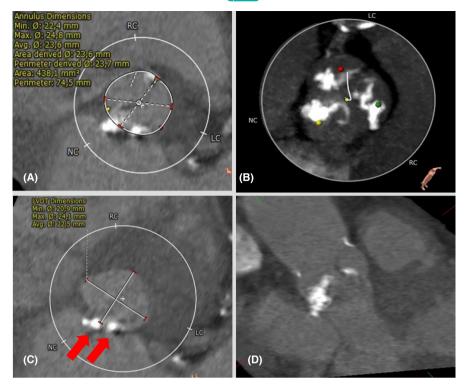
Pre-TAVR multi-slice CCT showing (A) annular sizing, (B) valve calcification, (C) short-axis view of the LVOT with two calcific nodules (red arrows), (D) long-axis view of the LVOT. CCT: cardiac computed tomography. LVOT: left-ventricle outflow tract.
